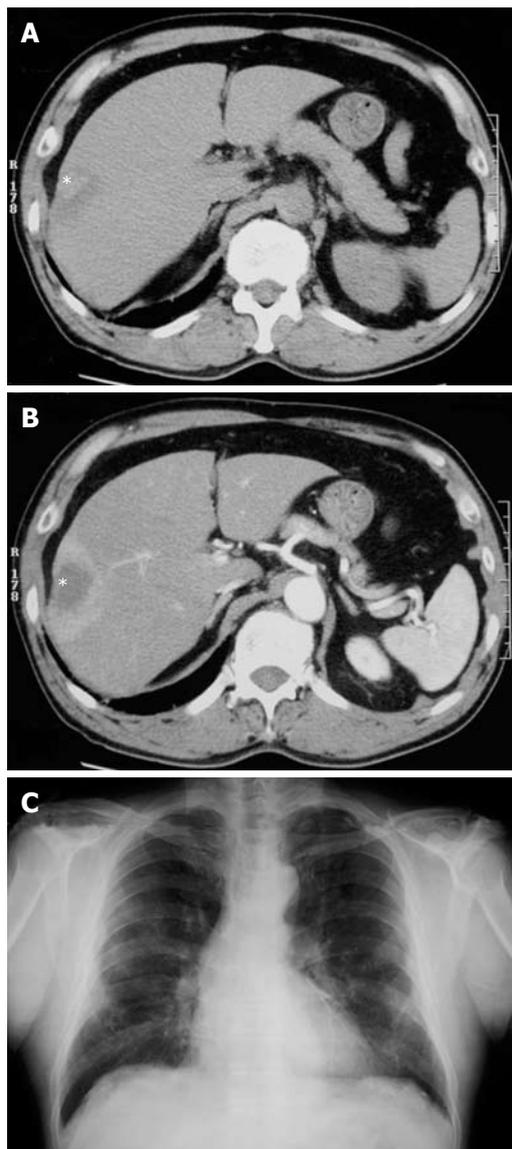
Radiological findings. A: Plain CT showed a low-density mass (asterisk) in S8 segment of the liver; B: The periphery of the mass (asterisk) was enhanced in the early phase of enhanced CT, suggesting abundant blood supply; C: Chest X-ray showed pulmonary asbestosis and pleural thickening, but there were no new lesions suggesting lung cancer or pleural mesothelioma.
